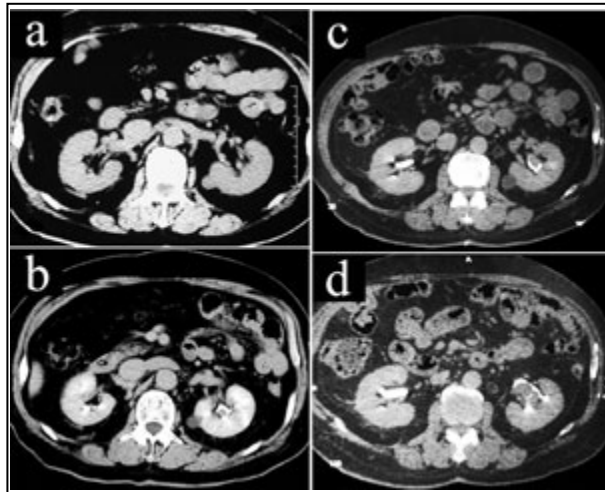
The plain and enhanced CT scanning showed the development of the lesion in left renal pelvis.
